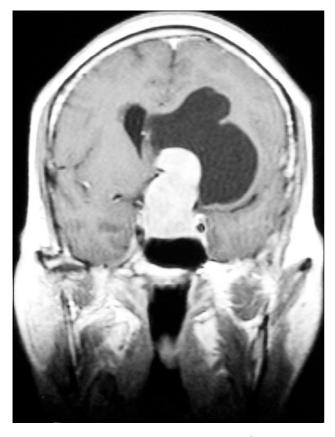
A solid sellar mass lesion with suprasellar extensions and a large supra-parasellar cystic cavity are seen on the T1-W postcontrast coronal MRI. Hyperintensely-enhanced pituitary adenoma and an arachnoid cyst compress left lateral ventricle. It is noticed that the cyst is slightly hypointense compared to the lateral ventricles.
